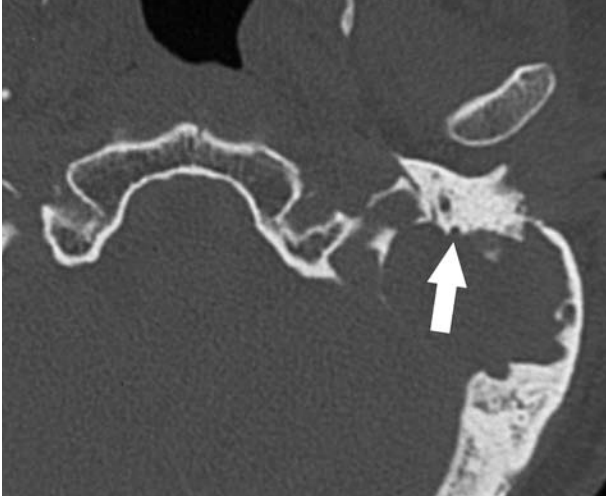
CT scan shows that posterior surface of mastoid portion of facial nerve (arrow) has been exposed by lesion.
